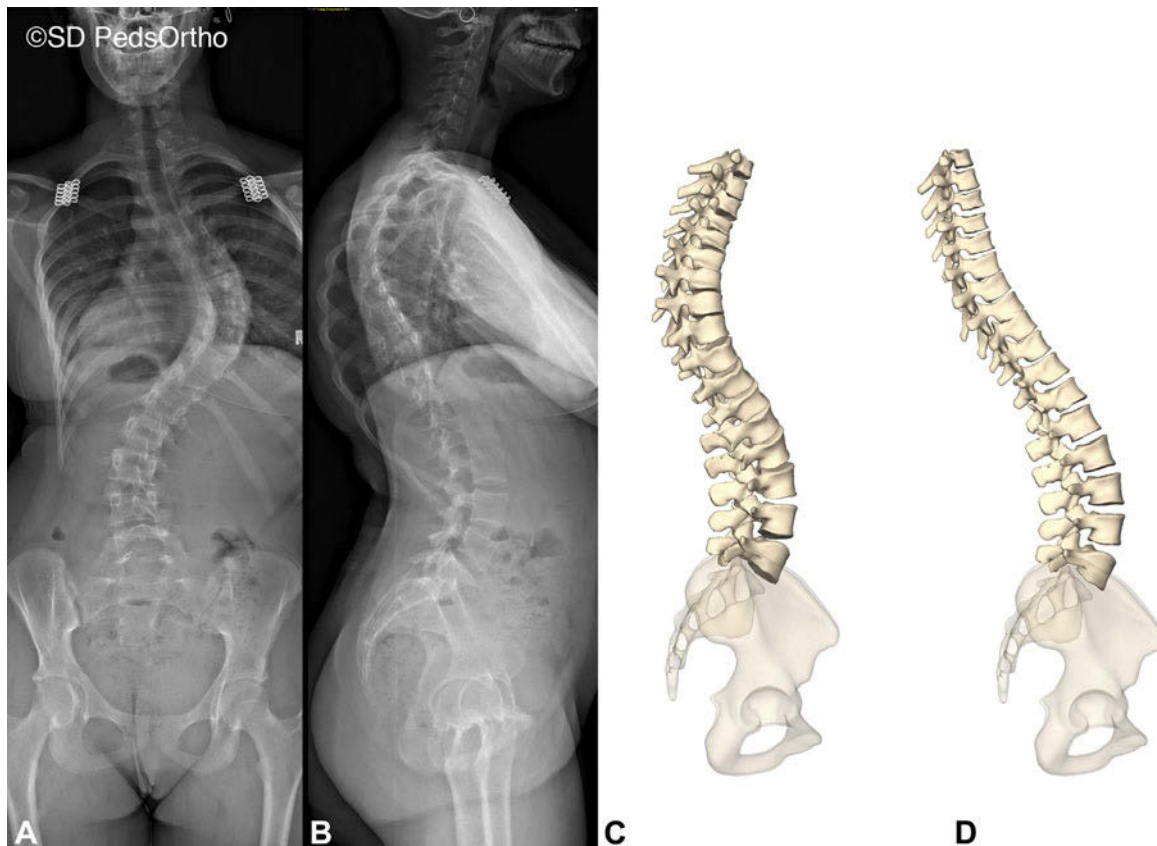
The 2D radiographs (A, B) and the 3D reconstructed lateral image in the traditional global reference frame (C) underestimate the hypokyphosis that is observed with the 3D reconstructed model using the summed segmental method (D) that “restacks” each motion segment in its respective plane, eliminating the influence of the coronal and axial deformities on the sagittal plane.
